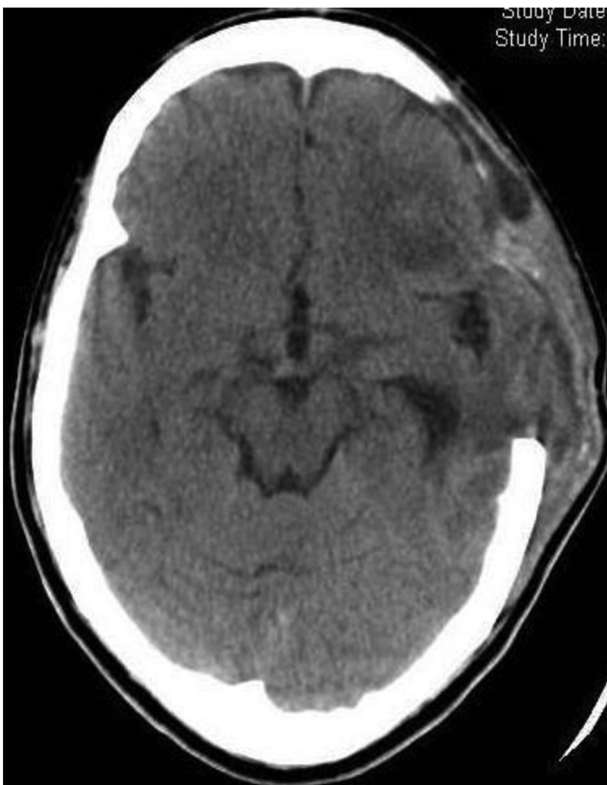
Postoperative computed tomographic scan of the brain: resolution of the mass effect.
